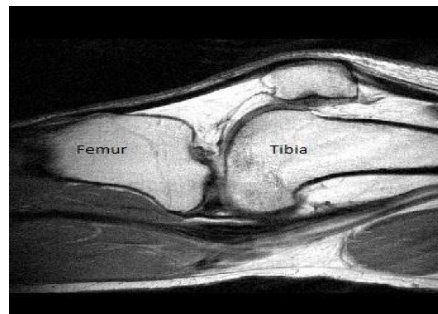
MRI image of right knee
